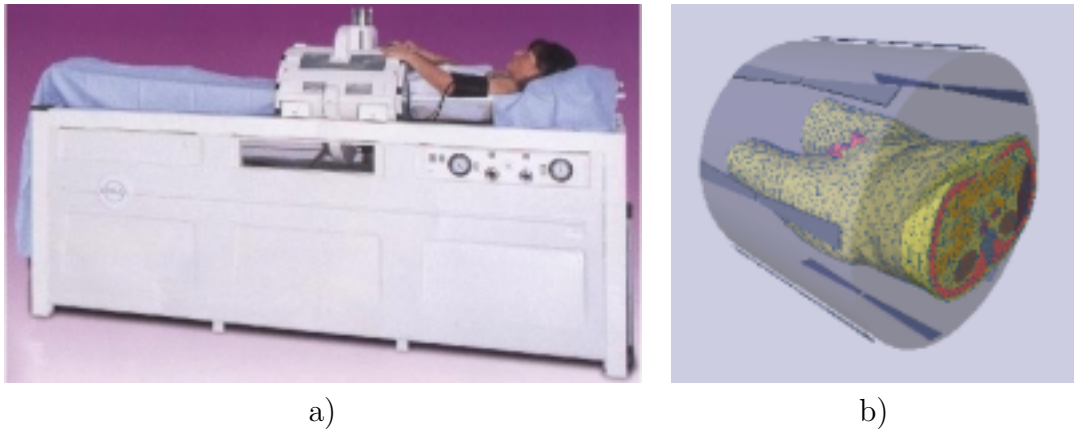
BSD2000 device as an example of regional RF hyperthermia with annular array antennas (a) and a view of a treatment planning software (b), which identifies an internal organs based on magnetic resonance (MRI) slices. Such a device is very expensive, and a generation of a grid requires one day in order to adapt data obtained from the MRI*
